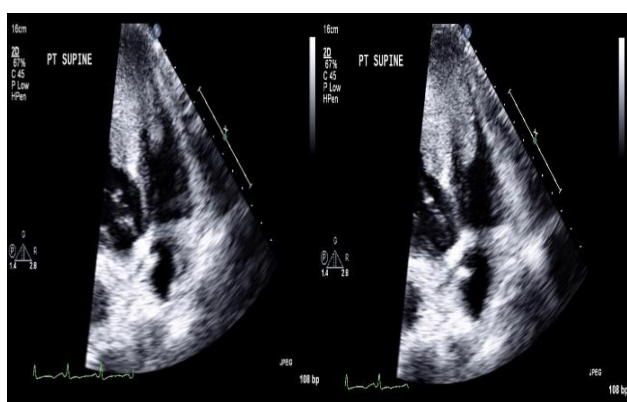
Echocardiogram revealing the mass on both the left and right ventricle.
